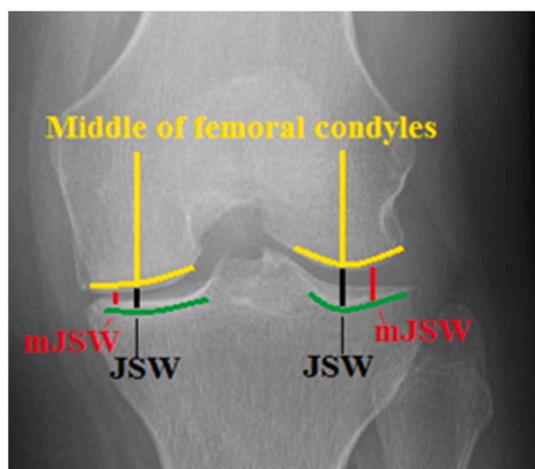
Radiographic measurements of JSW and mJSW in specialized radiographs.
